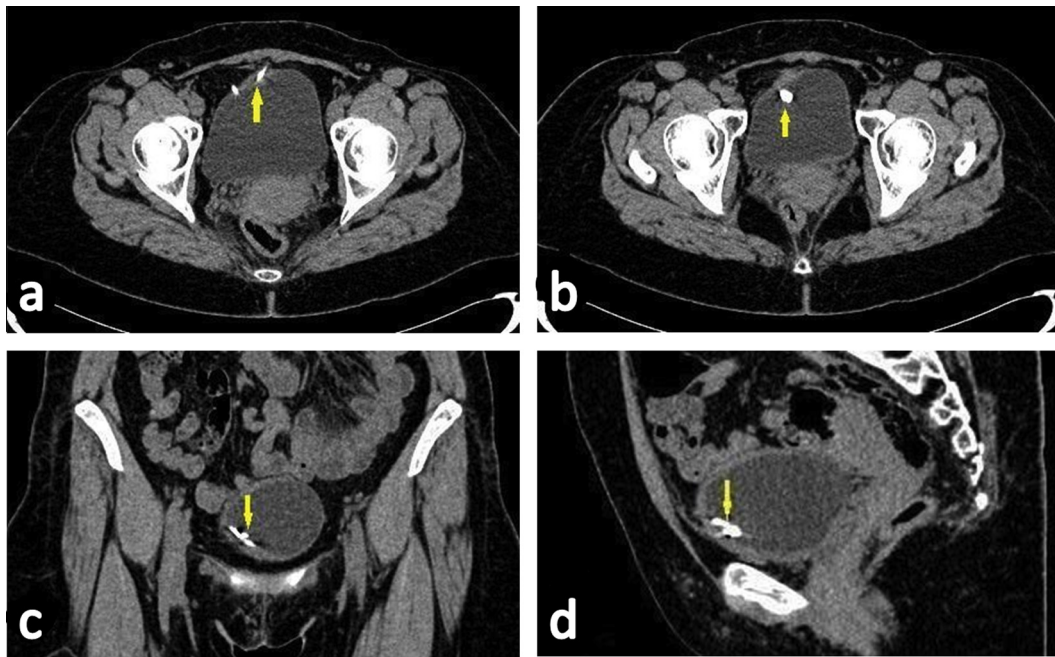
Forty-one year old female patient with dysuria and hematuria. CT stone protocol revealed a contraceptive device that penetrated into the urinary bladder lumen. (a) Axial cut at the urinary bladder showing the two limbs of the device (arrow). (b) Axial cut at a lower level showing the stem of the device (arrow). Coronal (c) and sagittal (d) showing the contraceptive device (arrows).
